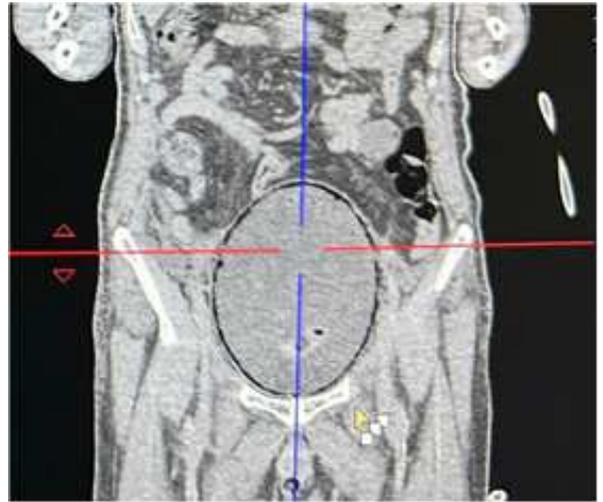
CT scan showing a coronal view of the patient showing the bladder wall outlined by mottled air bubbles
